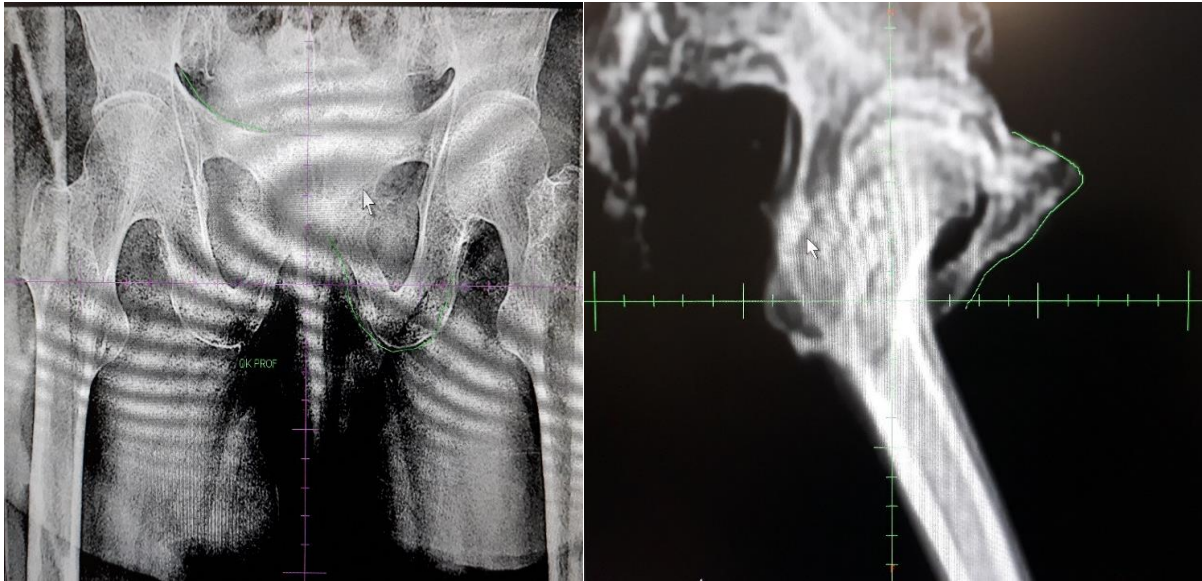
A Set of digitally reconstructed radiographs (DRR's), anterior-posterior and lateral views respectively, reconstructed from a planning CT at RBMI.
